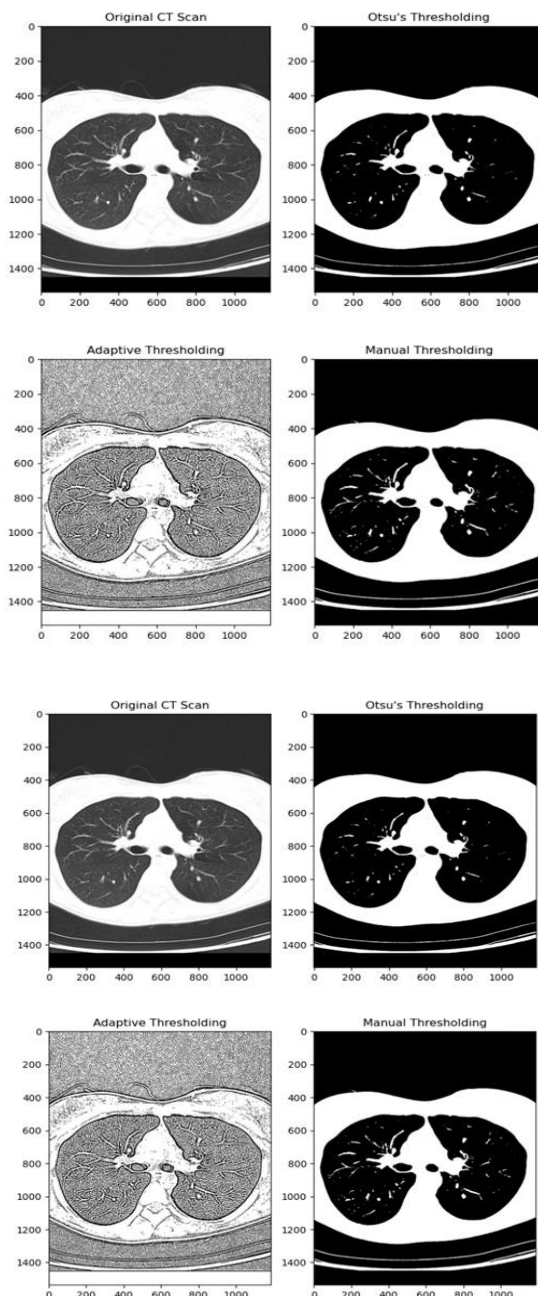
Thresholding Techniques Applied to CT Scan Image
